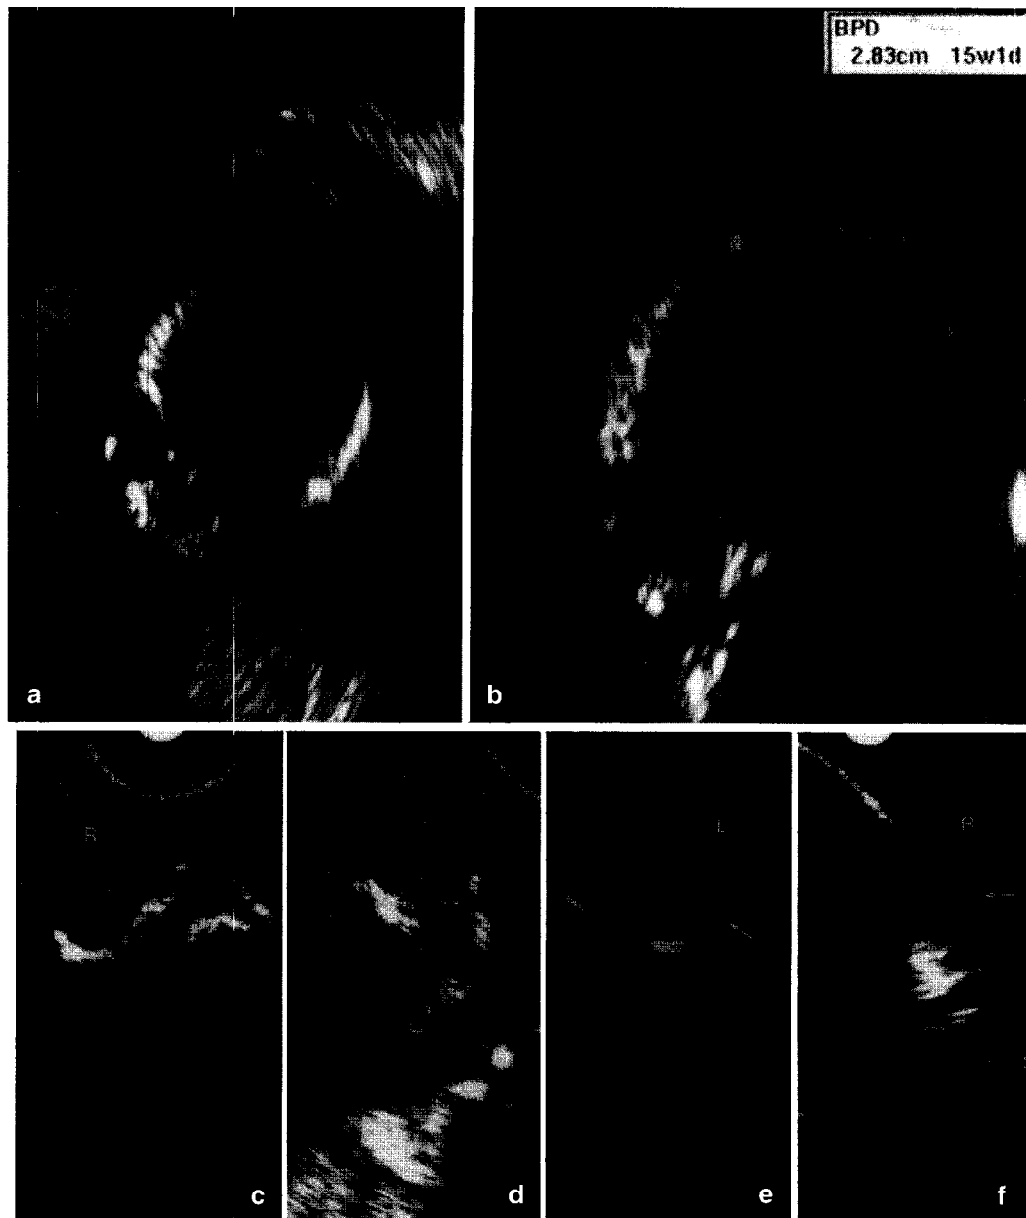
Sonographic images of the affected fetal eyes in the third pregnancy. (a) Coronal and (b) sagittal transvaginal image at 15 postmenstrual weeks. A certain degree of hyperechogenicity was seen. (c), (d), (e) and (f): Transabdominal views at 19 weeks obtained with the vaginal probe through the maternal umbilicus. (c) and (d) Coronal views of the right (R) and left (L) lenses. (e) and (f) Sagittal sections of the left (L) and right (R) lenses, respectively
